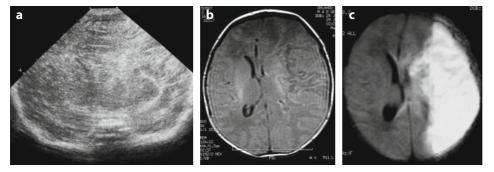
A large perinatal arterial infarct of the left middle cerebral artery is shown on all the scans: a US with area of increased echogenicity, b conventional MR axial T1 scan with evident midline shift and c even better from the huge area of restriction (*white*) at DWI. The baby was macrosomic, born by vaginal delivery and depressed at birth needing resuscitation and mechanical ventilation for a few hours
